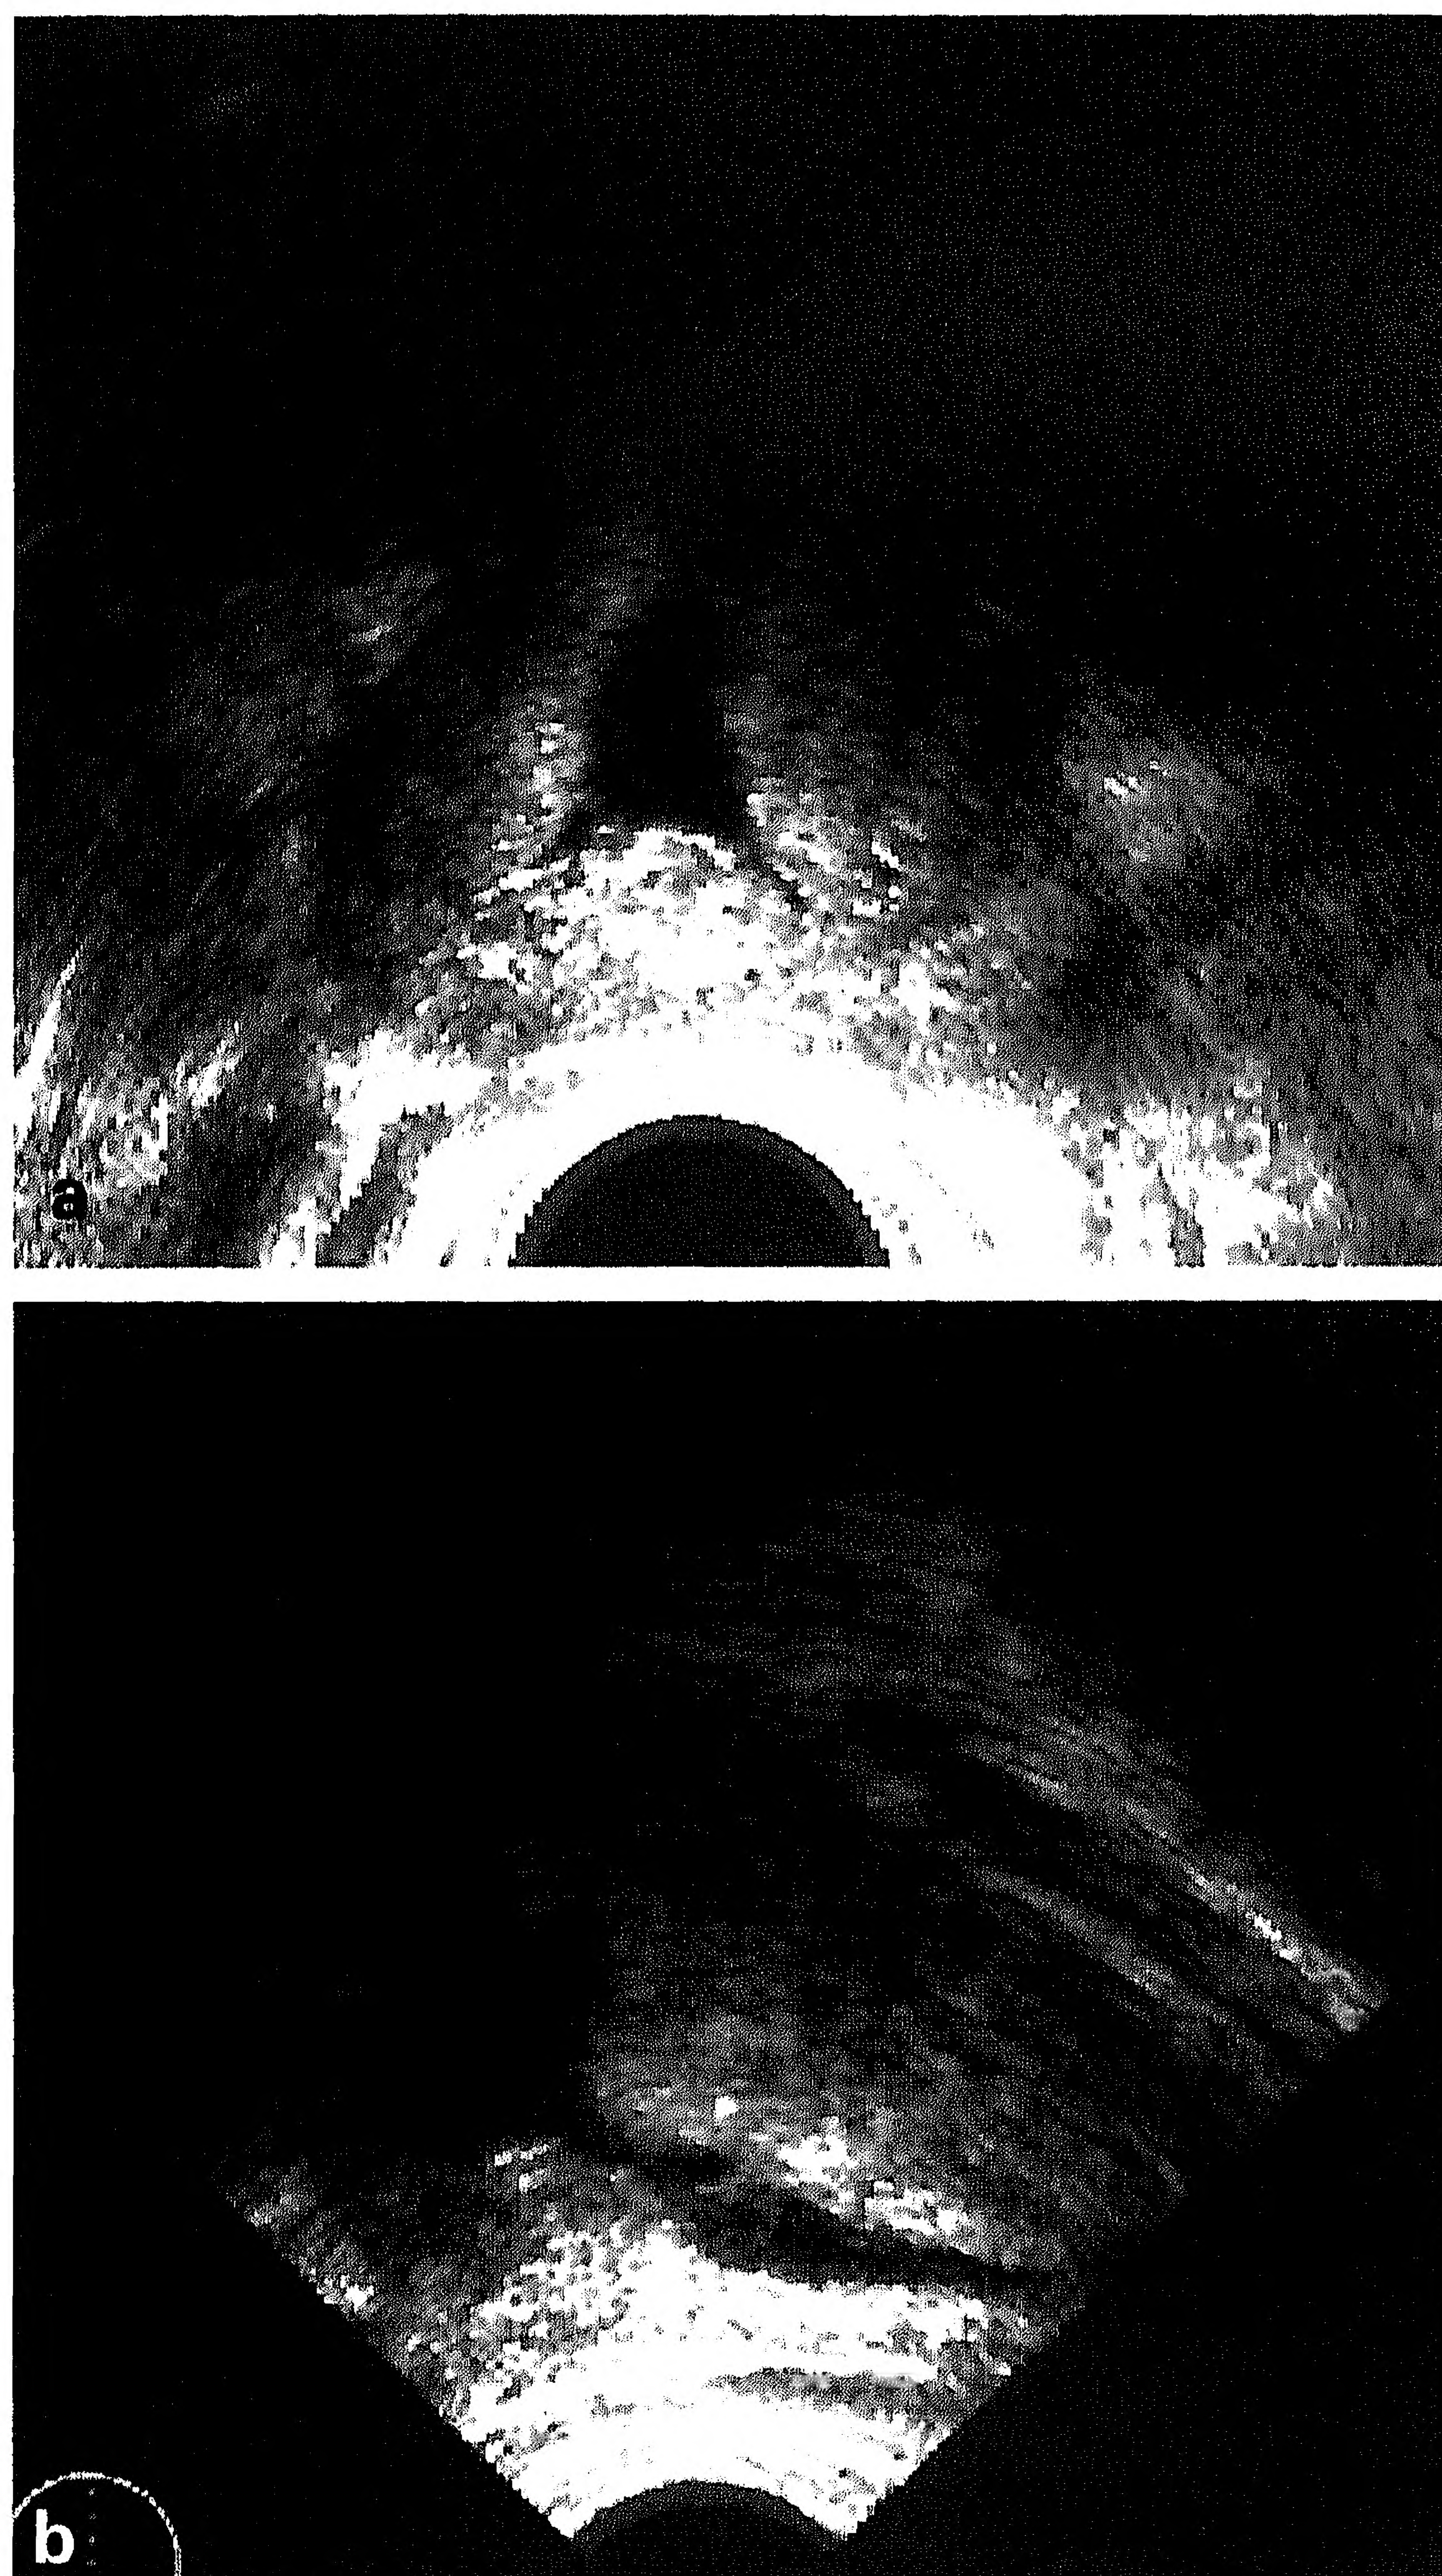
Ultrasonograms of the prostate showing cavity formation 3 months after TUMT using the Prostatron and Prostatsoft[®] 2.5. a, Transverse section. b, Longitudinal section.
